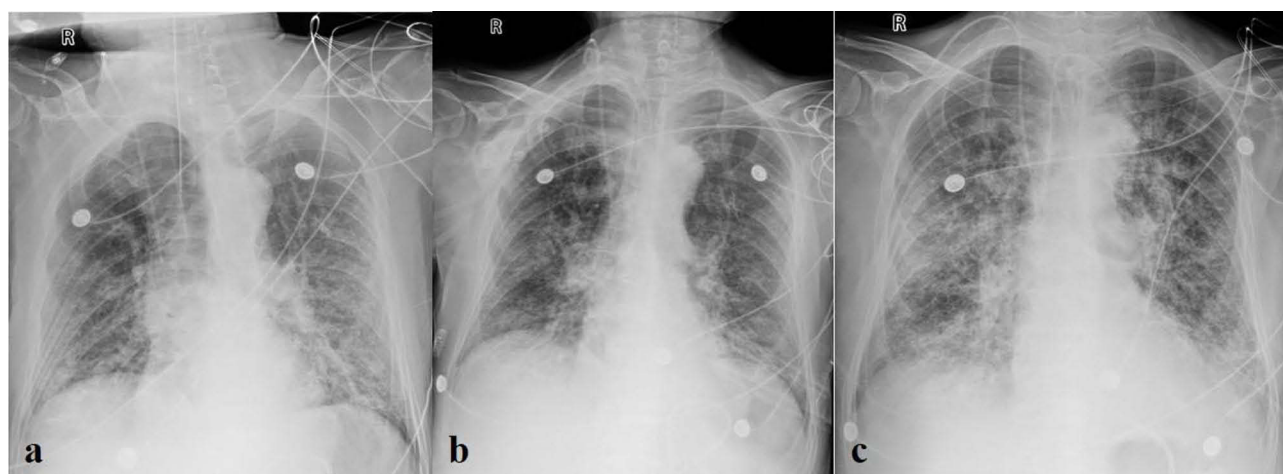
Chest X-ray (a) December 23, 2024: Both lung fields show patchy areas of increased density with blurred margins, suggestive of pneumonia. (b) December 31, 2024: Both lung fields show patchy areas of increased density, which have slightly decreased compared to previous findings, suggesting a slight improvement in the inflammation of both upper lungs. (c) January 4, 2025: Both lung fields show patchy, fluffy, and linear dense shadows with blurred margins, suggesting progression of bilateral pulmonary inflammation.
